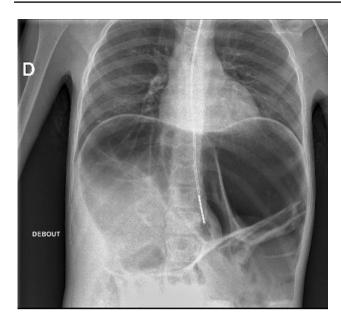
Abdomen X-ray at admission showing colectasia (11 cm)
